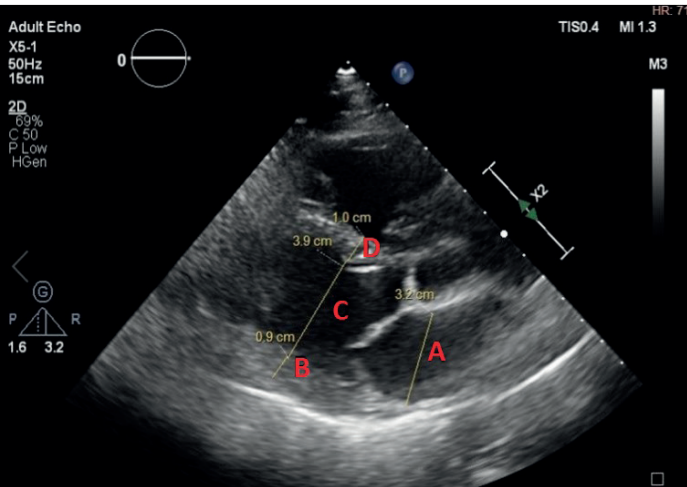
Representations of some measurements in transthoracic echocardiography. (A: Left atrium B: Posterior wall C: End diastolic ventricle diameter D: Interventricular septum)
